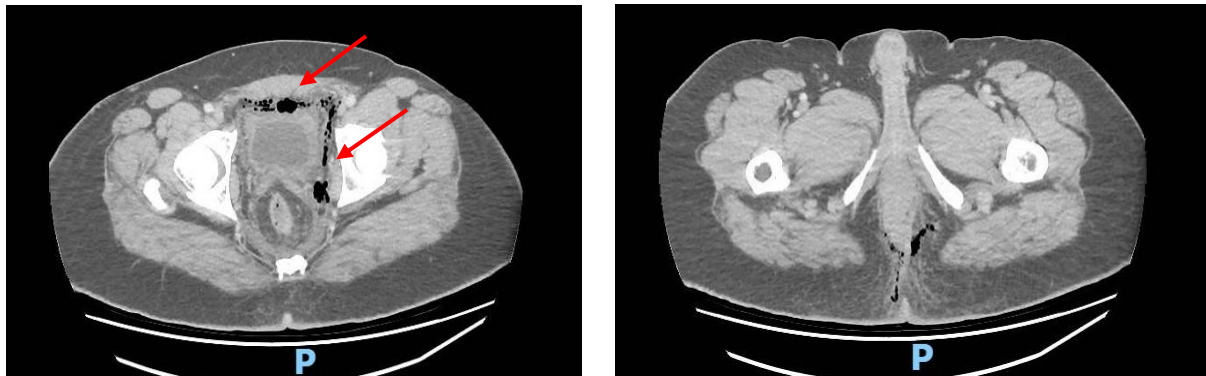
Axial CT images showing air in the perineal space bilaterally as well as air in the left pararectal/paravesical and retzius space.
